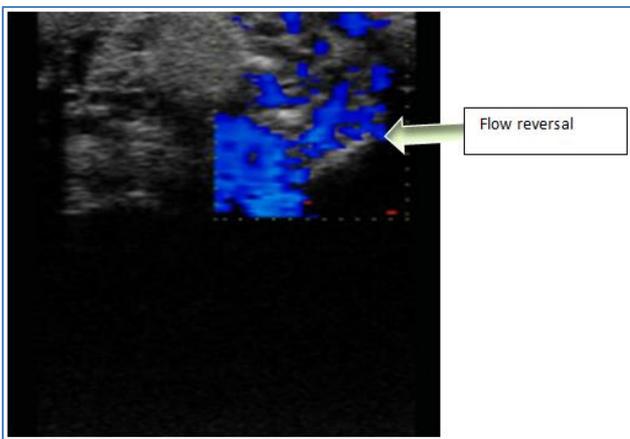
c: Color Doppler shows flow reversal on Valsalva manoeuvre (Flow reversal on colour Doppler)
